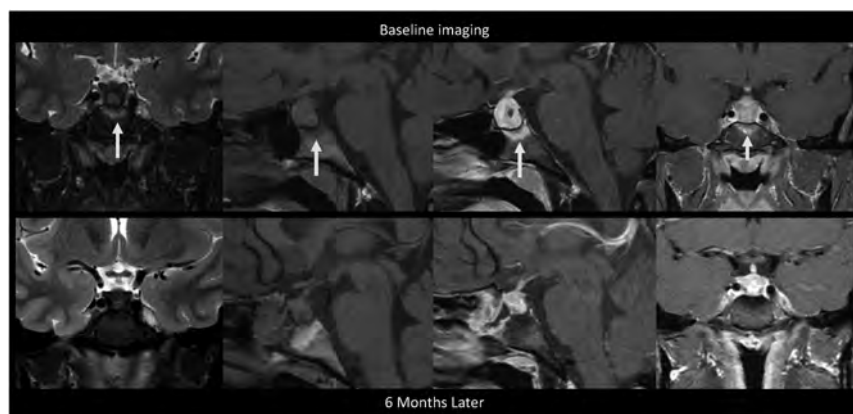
MR images of patient 2 with idiopathic GH and type 3 (sellar) sphenoid sinus pneumatization. This is a collage of images of a single patient at baseline before intervention (*upper row*) followed by postbiopsy and post-steroid treatment. *Left to right*, Coronal T2-weighted, precontrast sagittal T1-weighted, fat-saturated postcontrast sagittal T1-weighted, and fat-saturated postcontrast coronal T1-weighted images show diffuse infrasellar basisphenoid bone marrow-enhancing edema (*arrows*) on baseline that resolved 6 months later after biopsy and steroids.
